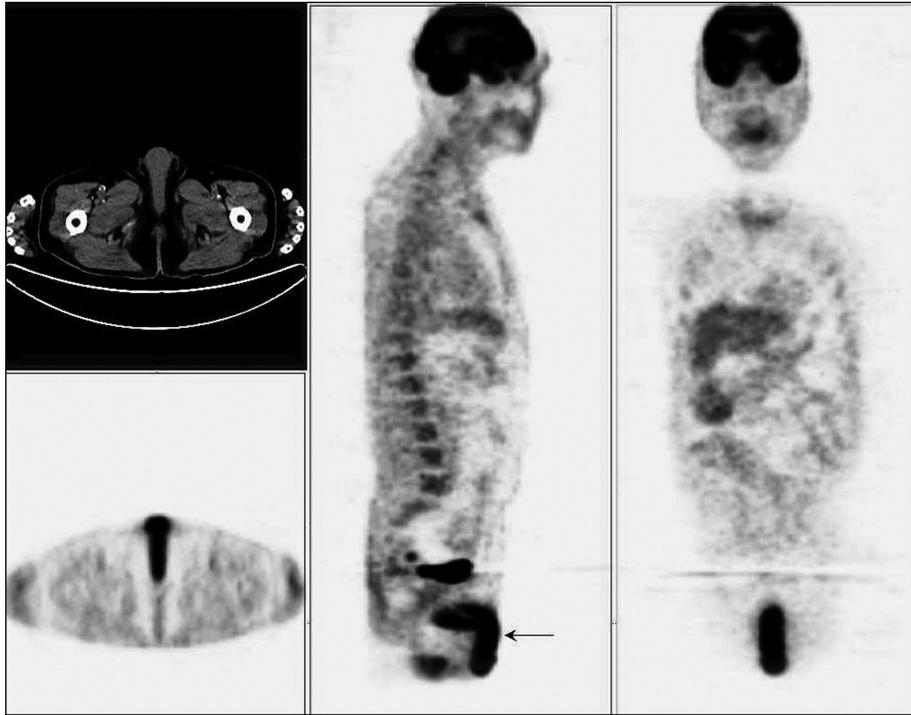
An 80-year-old man presented with intermittent fever of past 2 months. He reported loss of appetite and subsequent weight loss. Penile lymphoma may present with ulcer, mass, and diffuse swelling. However, the present case had no demonstrable abnormality on local examination.^{1,2} His blood cytology and blood biochemistry was unremarkable. The liver functions and renal functions were within normal limits. Ultrasonography of abdomen was normal. Chest radiograph and CT of the abdomen and pelvis were normal. He was referred for a whole-body F-18 FDG PET/CT scan. The study revealed intense metabolic activity within the penis (arrow). However, the corresponding CT scan did not reveal any abnormality within the penis. Clinically, there were no signs of inflammation in the genitals. On a follow-up visit, tenderness was observed during per rectal examination. Another follow-up sonography revealed inflammation in the epididymis. Hence, he underwent biopsy of the testicle and scrotal tissue. The causes of pyrexia of unknown origin (PUO) can be divided into infectious, malignancy, autoimmune, and others. Tuberculosis, abdominal, pelvic, dental abscesses, infective endocarditis, and prostatitis are some of the common infectious causes of PUO. Lymphoma, chronic leukemia, renal cell carcinoma, hepatoma, and colon carcinomas are some of the malignant conditions for PUO. Rheumatic fever, rheumatoid arthritis, systemic lupus erythematosus, and temporal arteritis are some of the causes of autoimmune disorders, which are accounting for PUO. Certain drugs, sarcoidosis, and deep vein thrombosis are some other causes of PUO. After thorough clinical examination, blood culture, serology, the imaging tests including chest radiograph, ultrasonography, CT, and MRI of relevant regions, and transesophageal echocardiography were performed for evidence of infective endocarditis. The nuclear medicine procedures included Technetium 99m-Methylene diphosphonate skeletal scintigraphy, Gallium-67 citrate for occult infection, sarcoidosis, and malignancy, Tc-99m-WBC scan for abdominal or pelvic infections. Positron emission tomography using Fluorine-18-Fluorodeoxyglucose may be performed to look for occult infection or neoplasm as in the present case.
